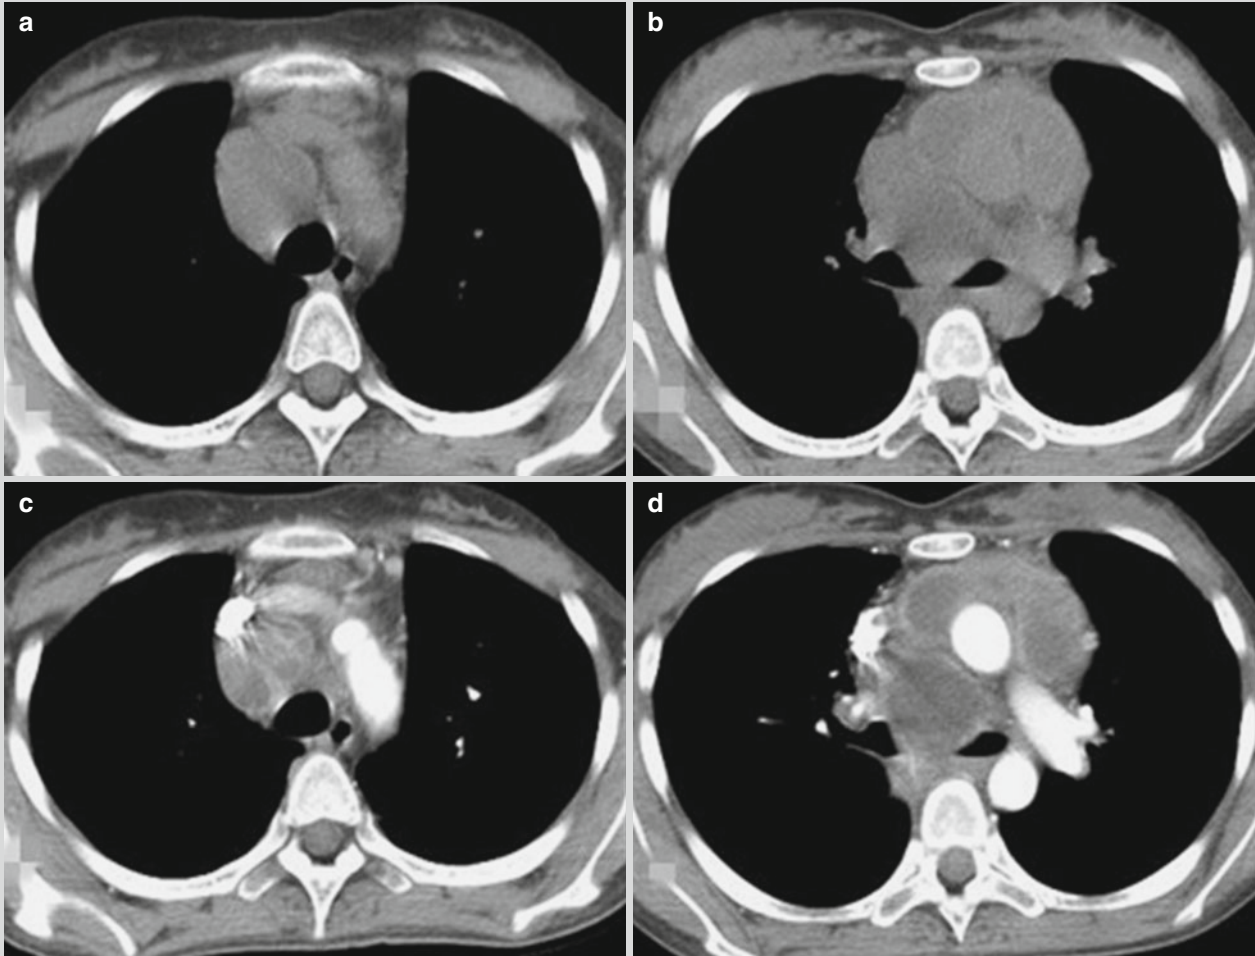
Mediastinal lymphatic TB. (a, b) Plain CT scanning demonstrates swollen lymph nodes at the 3R and 4R areas of the mediastinum, absent adipose space between some of the lymph
